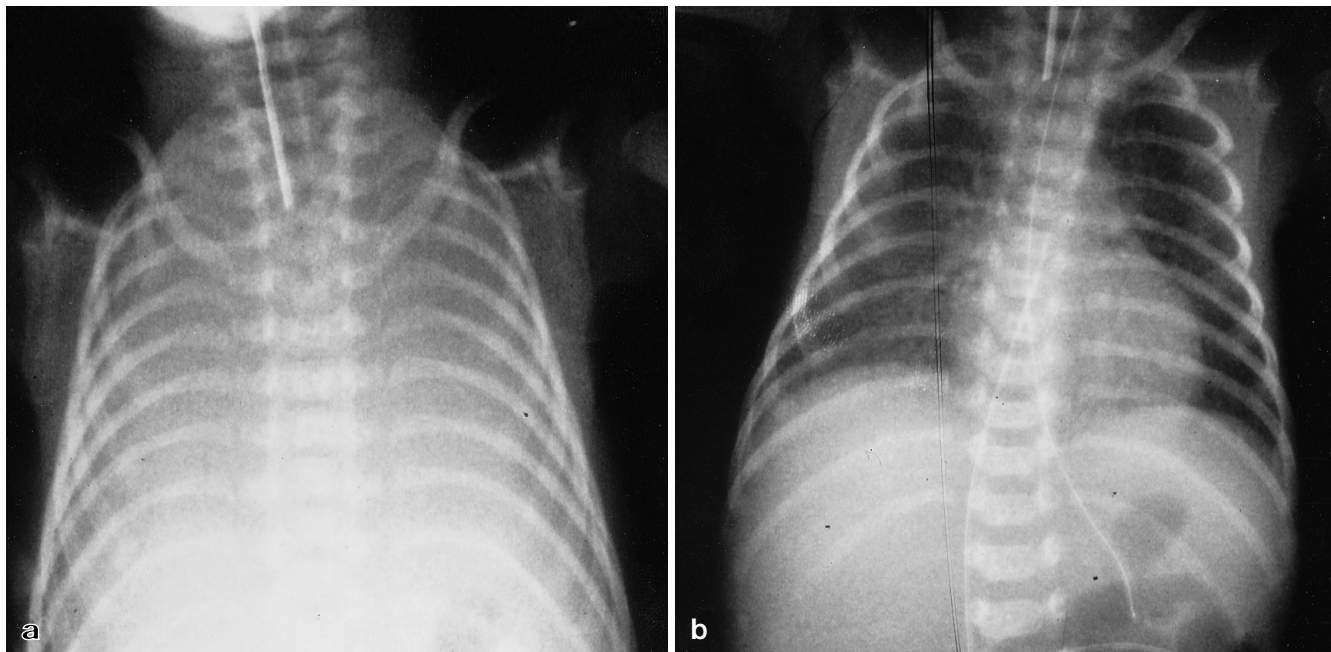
a, b Preterm infant [gestational age (GA) 26 weeks, 820 g] with severe respiratory distress syndrome (RDS): chest radiographs a before and b 4 h after surfactant instillation show uniform and complete improvement of aeration
